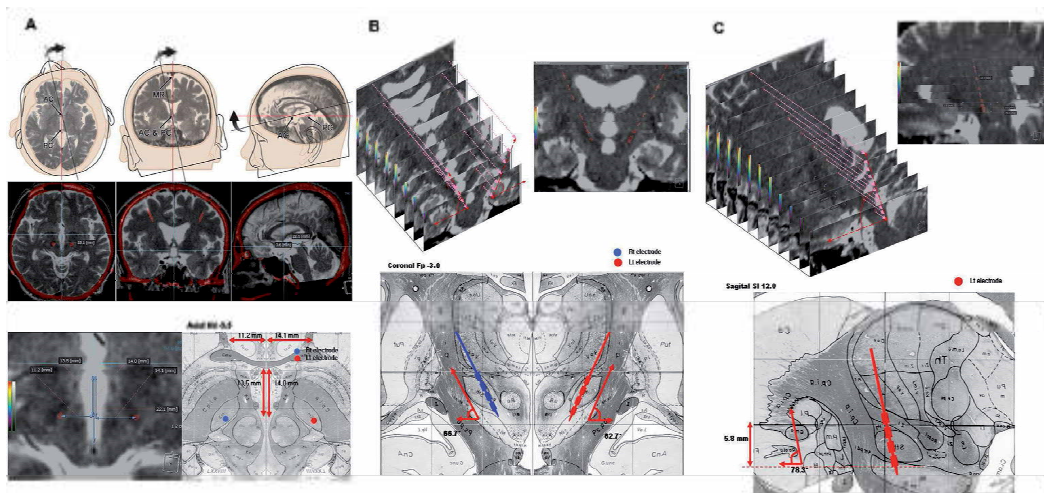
Image fusion of preoperative MRI and postoperative brain CT.
